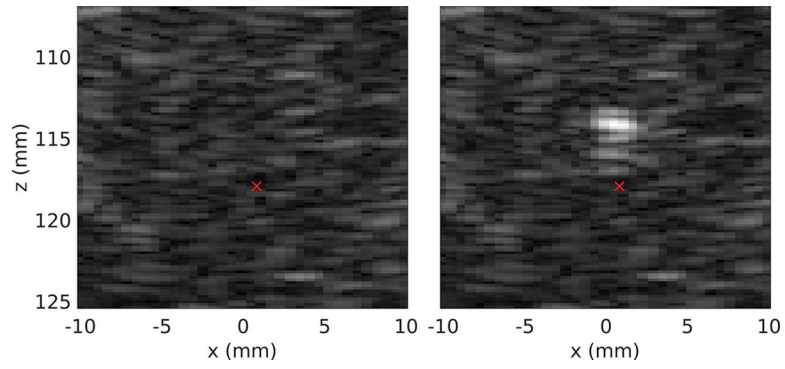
B-mode ultrasound imaging of the bodywall and liver with the inline ultrasound probe of the HIFU transducer. The red cross represents the HIFU geometric focus position.
